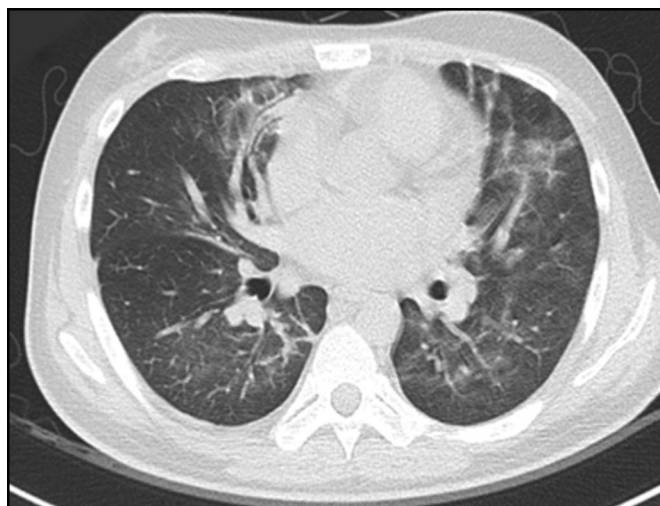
Thoracic computed tomography after 48 days of steroid use.
